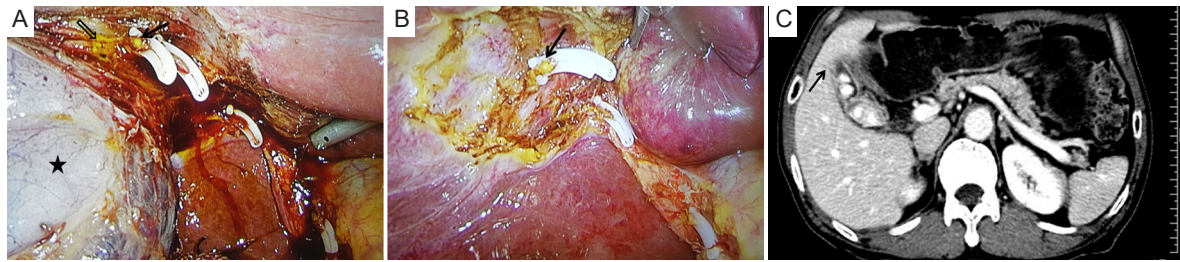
A. Intraoperative photo. During Laparoscopic cholecystectomy, when the detaching proceeded to the bottom of gallbladder (black star), a bile duct connecting the wall of gallbladder and cholecystic bed was encountered. The cystohepatic duct was cut off, and the photo showed the proximal cuff (black arrow) and distal cuff (hollow arrow). B. Intraoperative photo (gallbladder removed). The cystohepatic duct was clipped with hemolock and cut off subsequently after being identified, and the gallbladder was removed. The photo showed the proximal cuff (black arrow). C. Identifying the cystohepatic duct on image of computed tomography scan. Abdominal contrast-enhanced computed tomography scan showed the diameter of cystohepatic duct (black arrow) was 0.33 cm.
